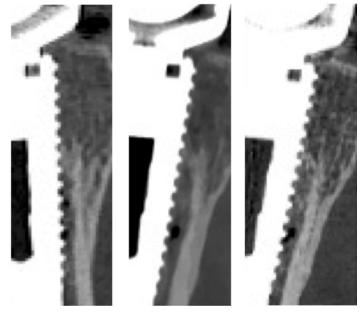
Coronal reconstructions of images obtained using (from the left) EID-CT, PCD-CT VMI and PCD-CT polyenergetic image showing the interface between the metal implant and bone. Streak artifacts are reduced in VMI reconstructions, while the trabecular structure is better visible in the polyenergetic image.
